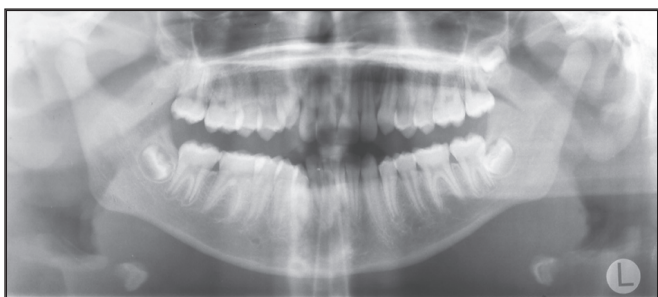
Panoramic radiograph showing no pathoses.
